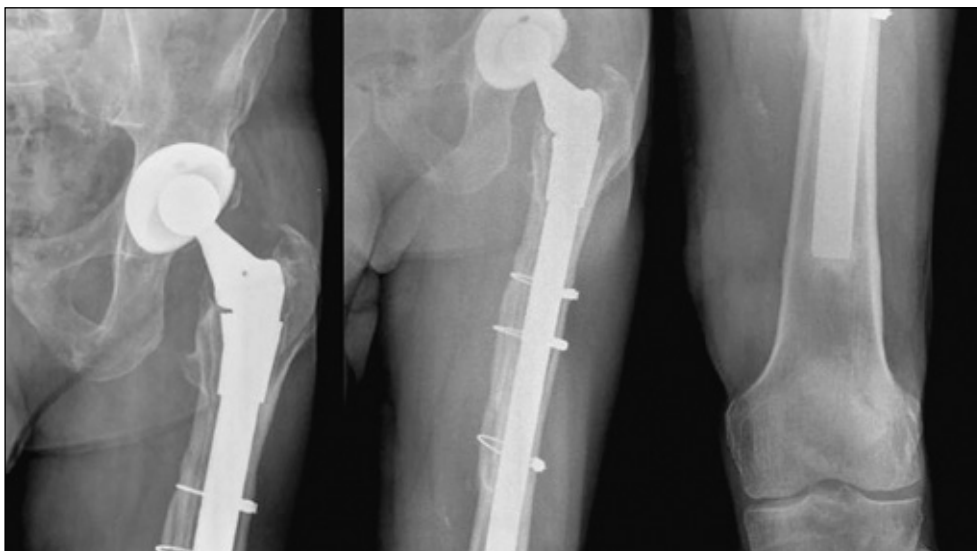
Anteroposterior radiographs of the left hip and femur eight years post-operatively.
